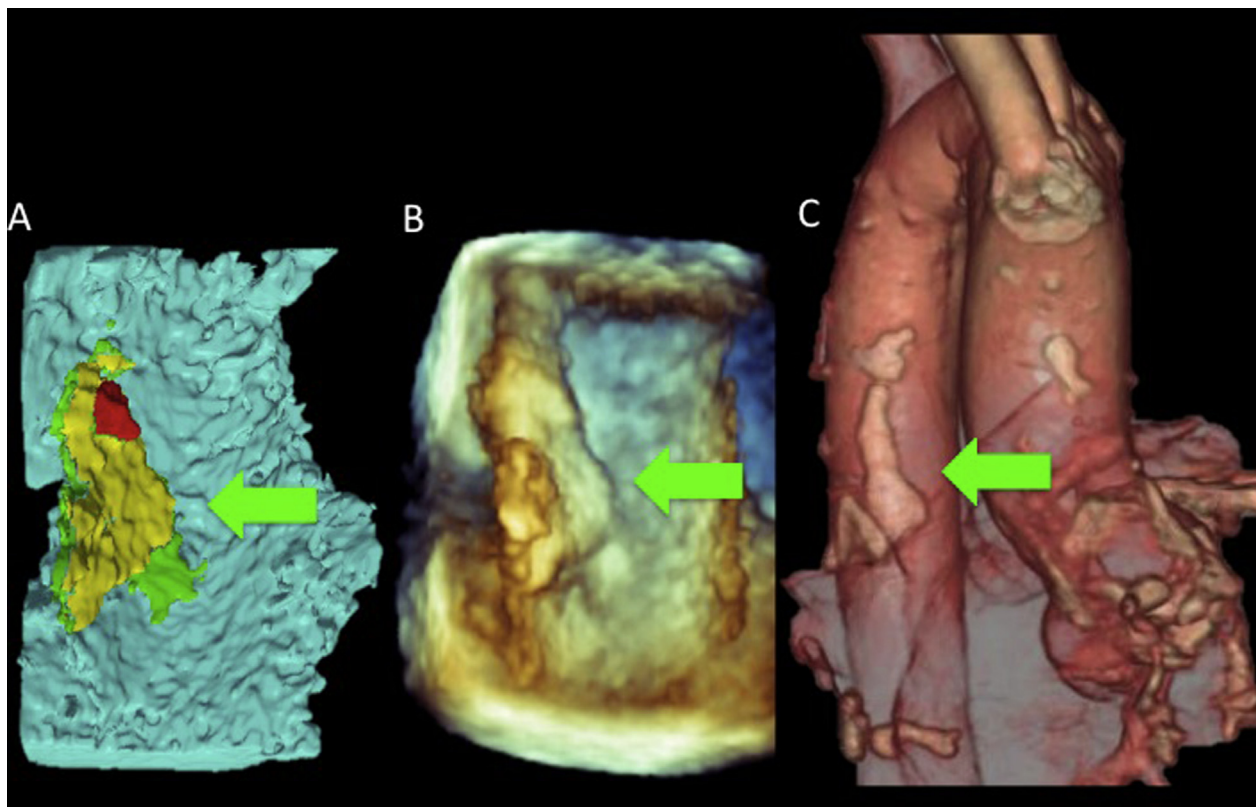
Example of a plaque visualized by the automated program, with severity highlighted by a three-level color map (A), the corresponding 3D rendered volumetric data (B), and on volume-rendered CT (C).
